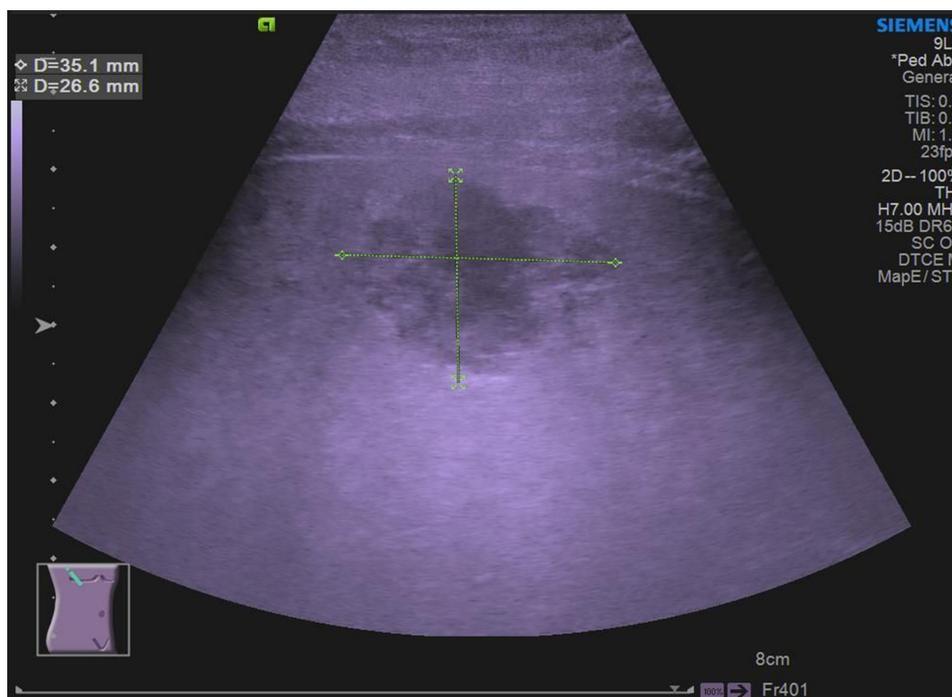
Abdominal ultrasound showed a right lobe liver abscess (mixed echoes, with a size of 3.5cm×2.7 cm).
